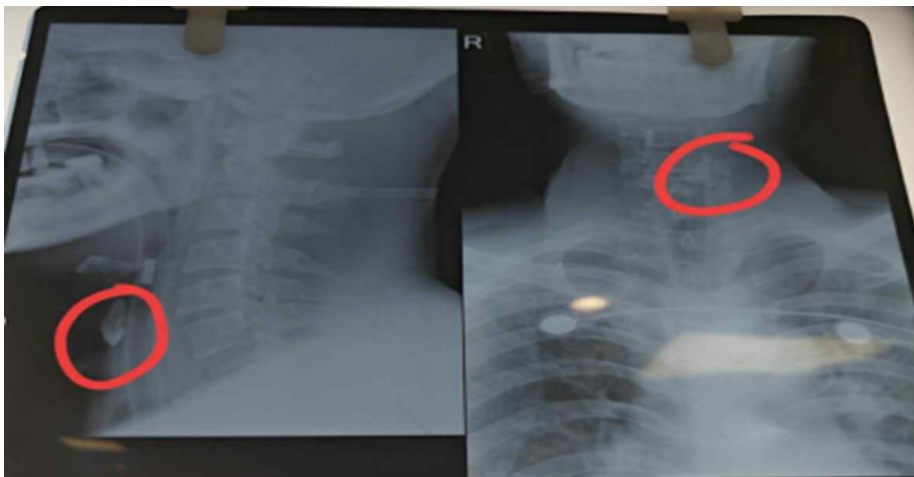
Neck and chest radiograph demonstrating a radiopaque foreign body consistent with a tooth within the trachea
